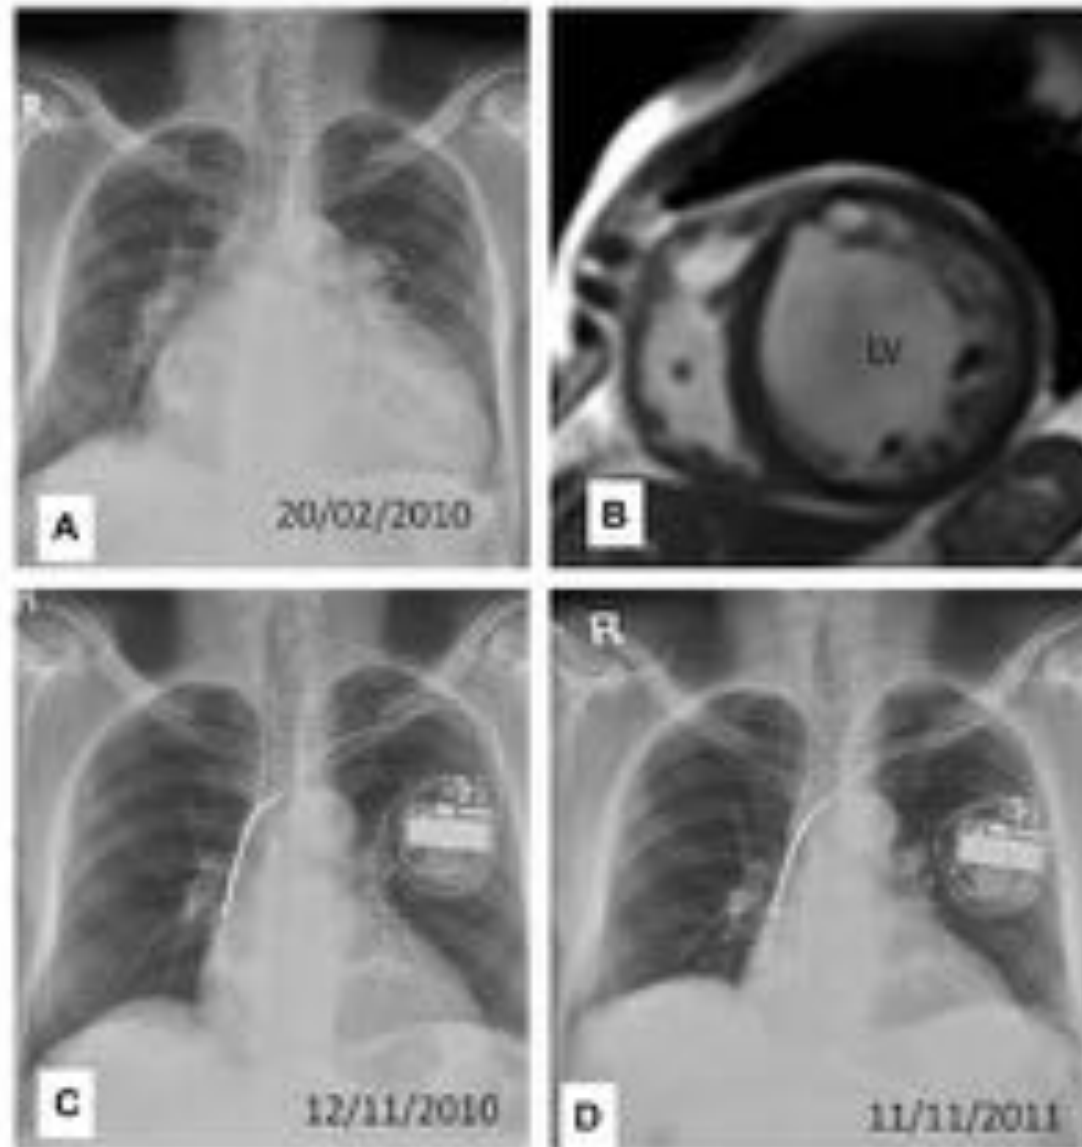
A & B - Baseline chest X ray and MR image; C & D - Serial follow up chest X ray images.
